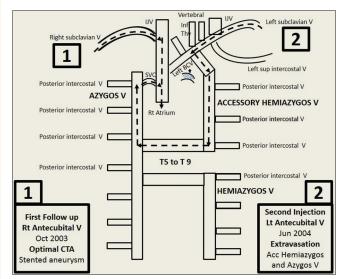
(D): At left is initial follow up CTA in Oct 2003 using a right antecubital vein displaying stented aneurysm; At right is follow up CTA in Jun 2004 using a left antecubital vein injection aborted due to an extravasation, predicted by absent free backflow in venflow. The alternate pathway was by accessory hemiazygos and azygos vein, probably a re-routing due to thoracic arch aortic aneurysm blocking the left brachiocephalic vein
